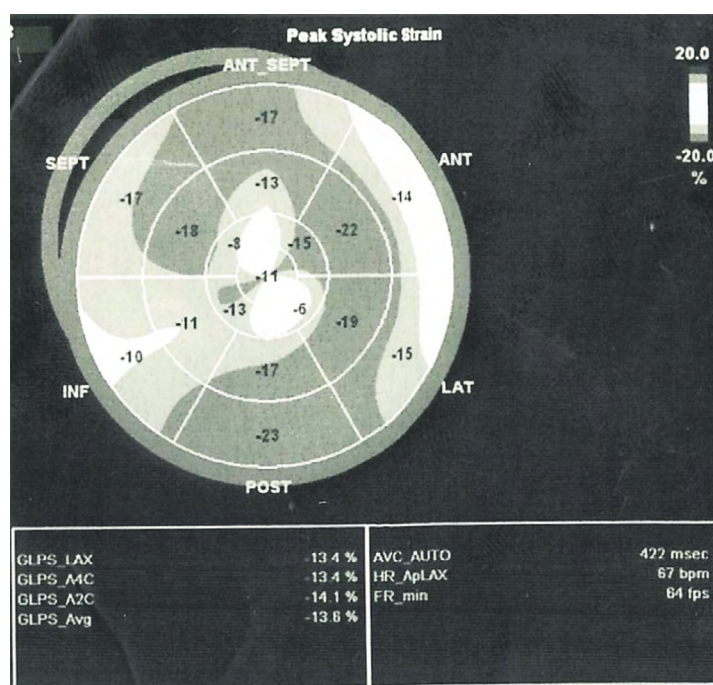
2D Speckle Tracking Echocardiography of patient 816. Left ventricular global longitudinal strain — 13,6 %
